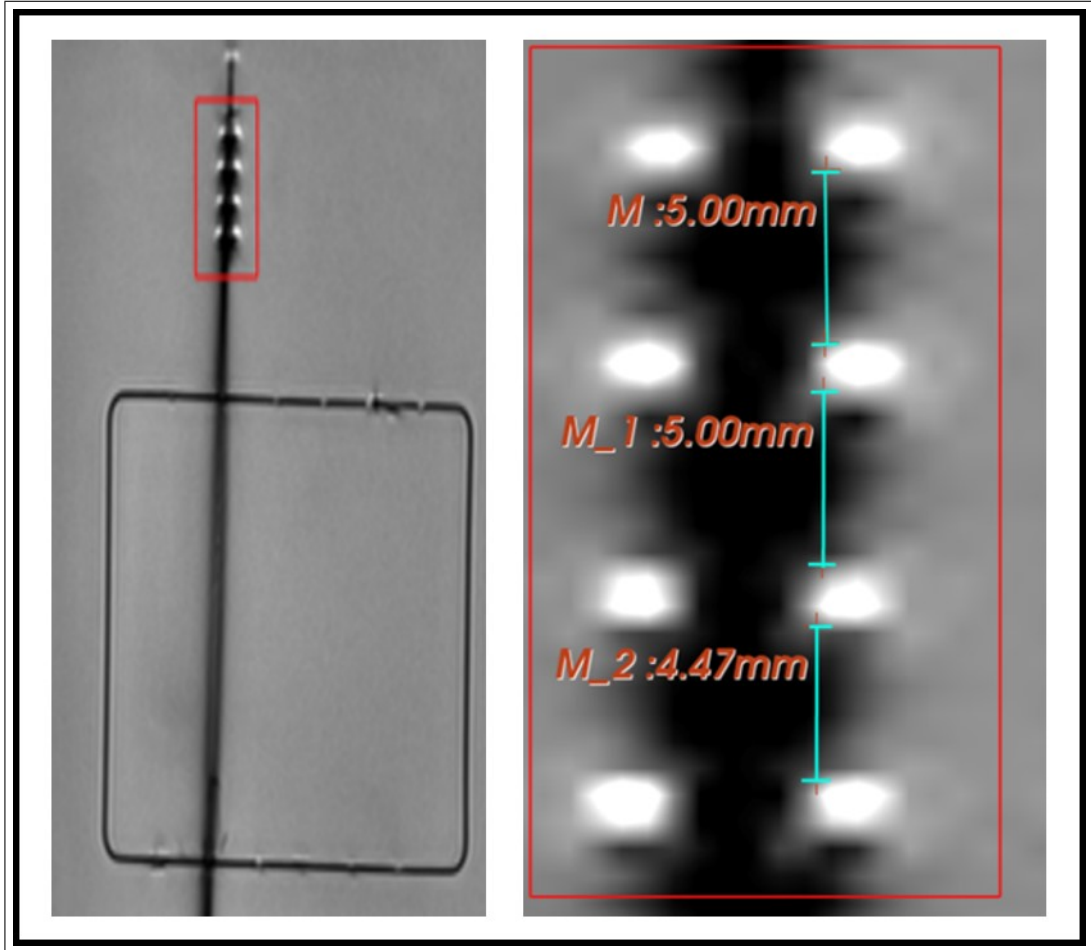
MRI image of the biopsy needle with Fe_2O_3 strips
